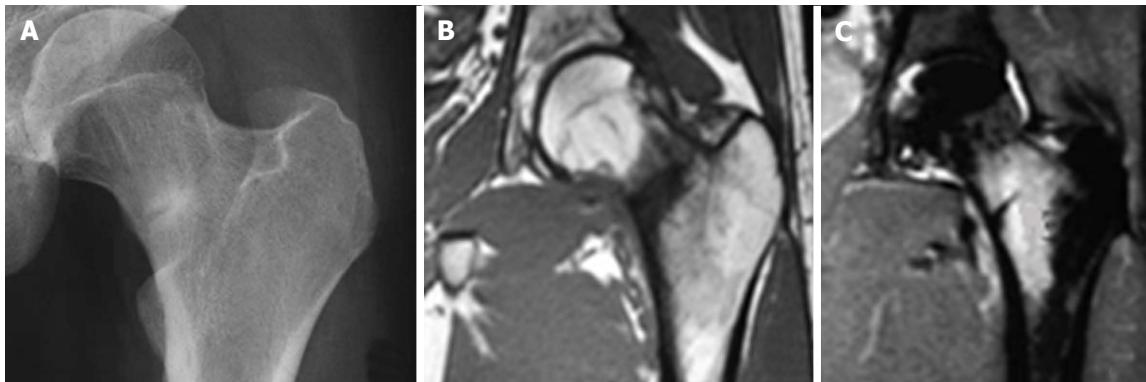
The management of an undisplaced compression sited femoral neck stress fracture. A: Diagnostic antero-posterior radiograph; B: Diagnostic T1 sequence coronal-plane magnetic resonance imaging (MRI) view; C: Diagnostic short tau inversion recovery sequence coronal-plane MRI view.
